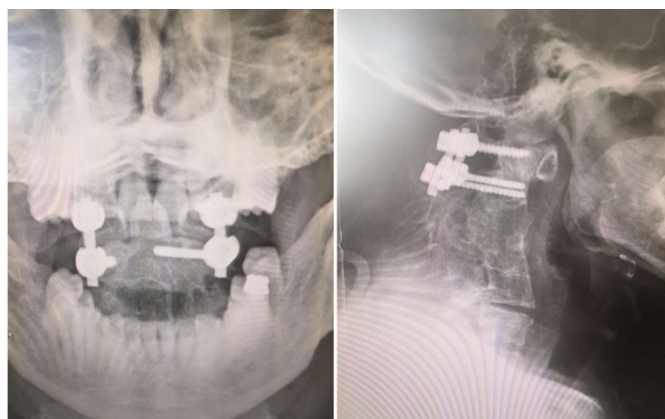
One year after operation, the lateral X-ray showed that C1-C2 internal fixation was not loose or broken, and the position was good. The space of odontoid process of atlantoaxial vertebra is asymmetrical, with the width on the left and the width on the right narrow, the upper and lower spaces of lateral mass are normal, no abnormality is found in bone, and the internal fixation is not loose or broken
